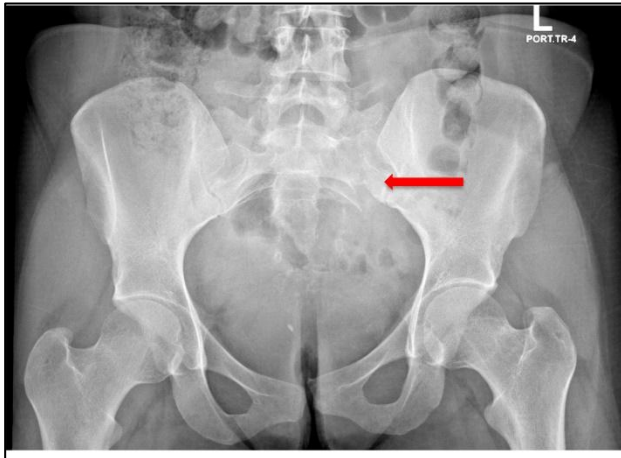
anteroposterior radiograph of the pelvis showing left sacral fracture (red arrow); there is no widening of the pubic symphysis and no other associated pelvic fractures.
